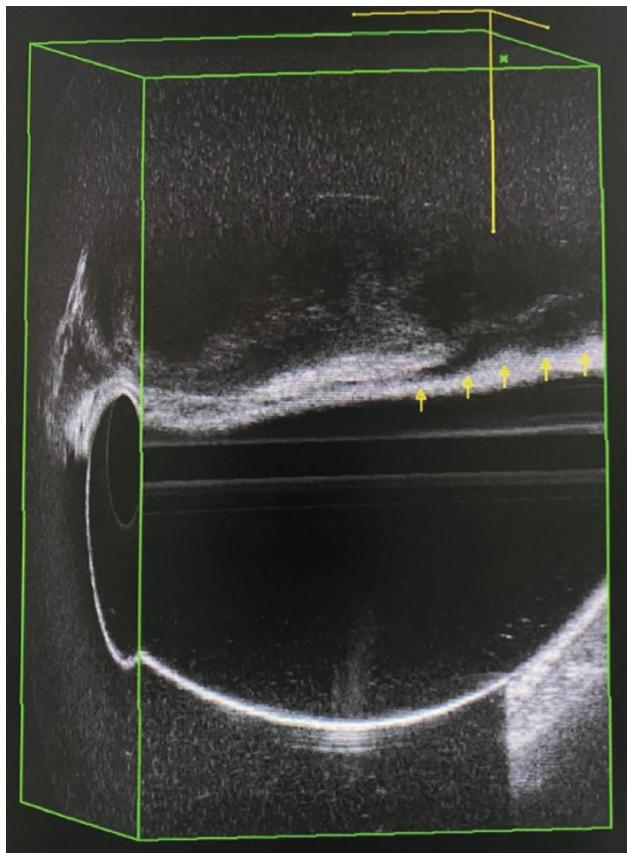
Endometriosis focus (arrows) evaluated by three-dimensional endorectal ultrasound (sagittal view) approximately 10 cm from the anal margin.
